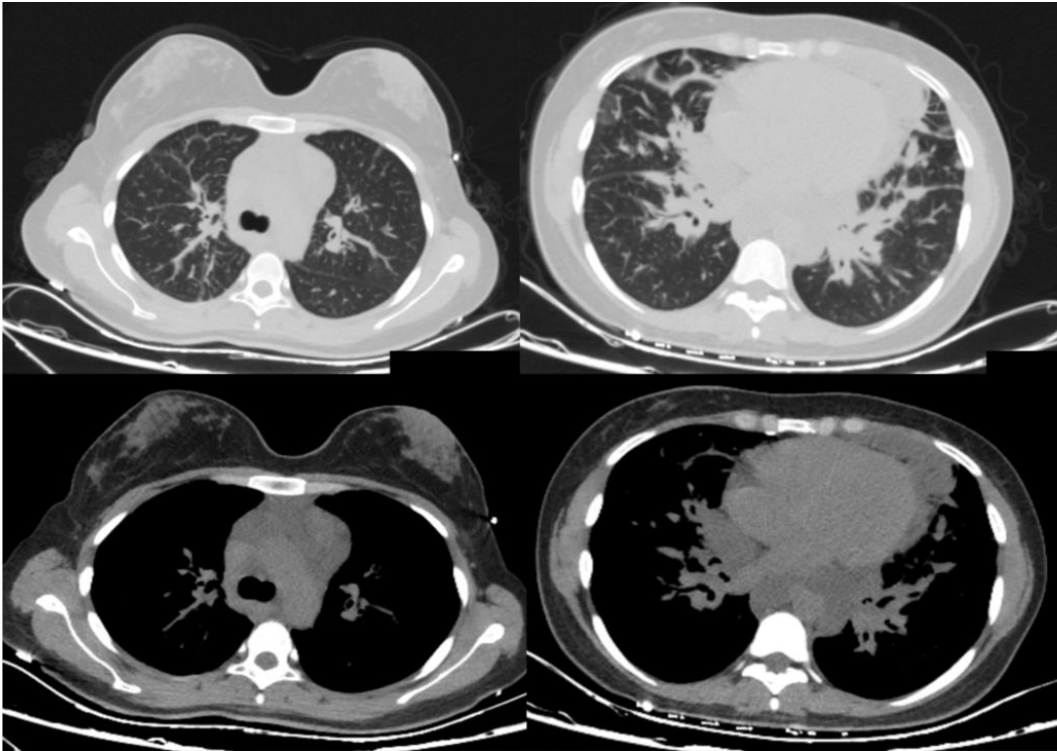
Chest computed tomography (CT) revealed diffuse and smooth interlobular septal thickening, peribronchovascular thickening, and patchy ground glass opacities (GGO). On the mediastinal window of the CT soft density at the hilum of the lung extending to the esophagus was seen
